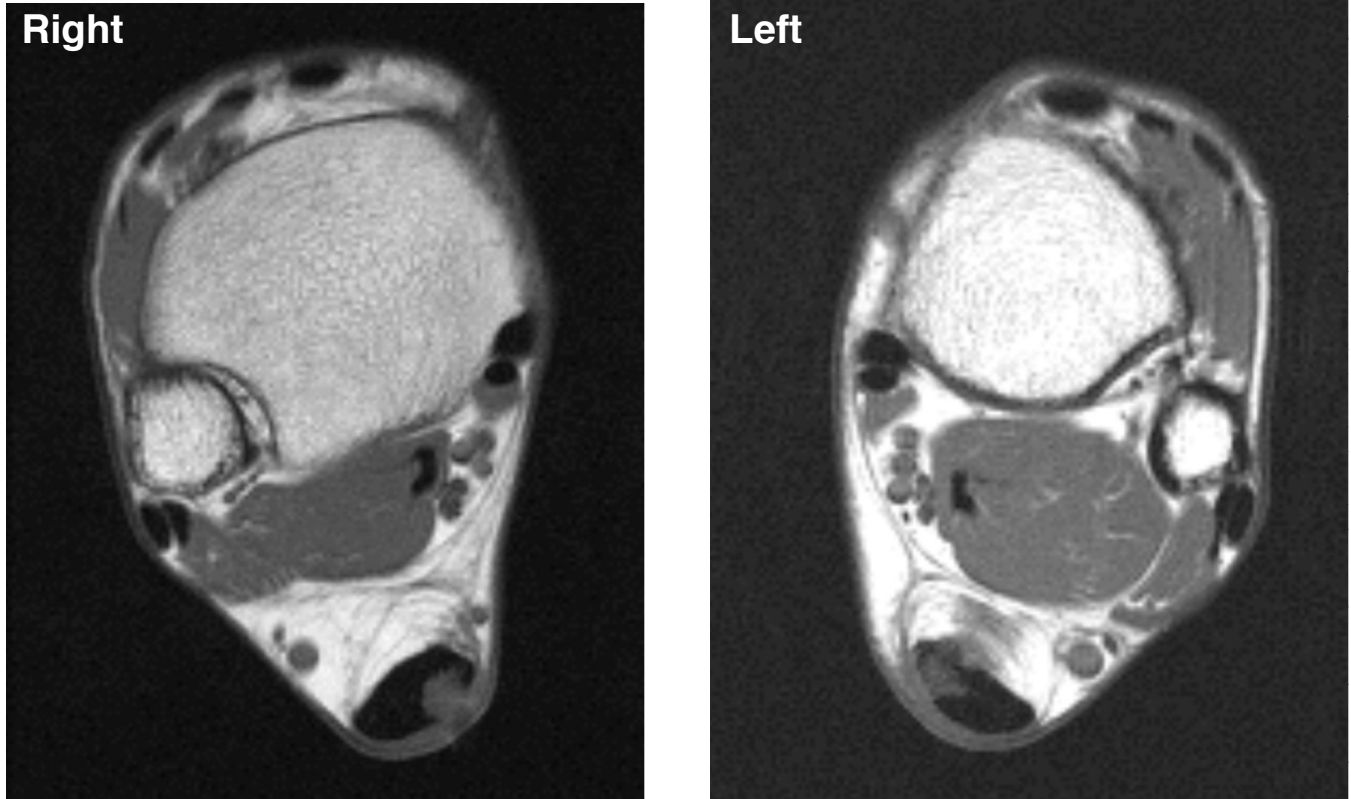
T1-weighted MRI obtained 18 days after onset of symptoms demonstrates small foci of increased signal in the medial-posterior margins of both tendons (R > L), suggestive of small partial width tears.
